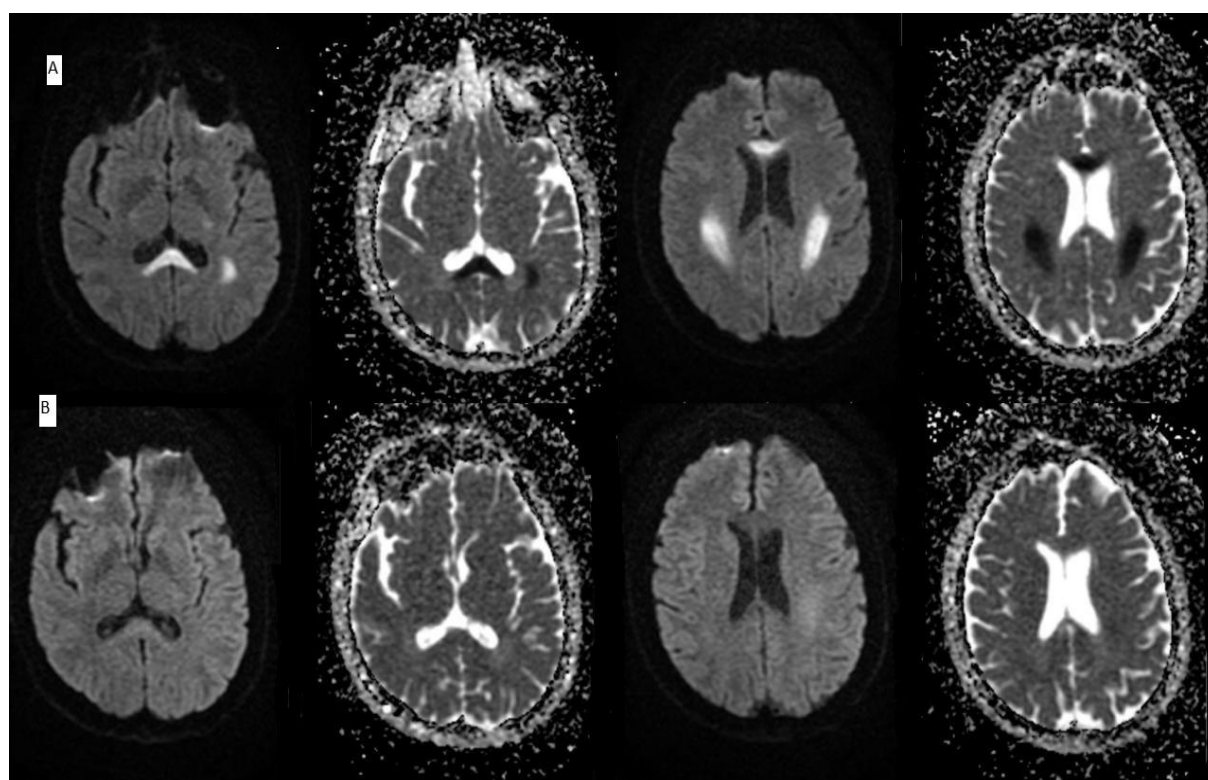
Diffusion-weighted MRI, A: Lesions before treatment, B: Recovery after treatment
